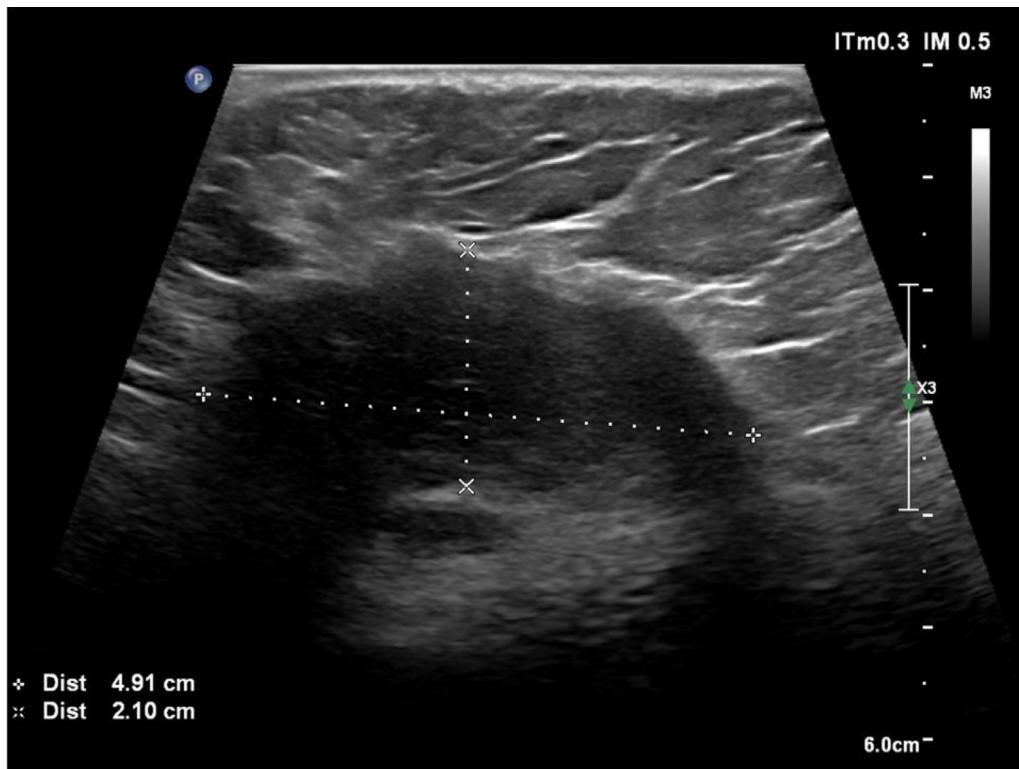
Right breast ultrasound image showing a hypoechoic, attenuating mass with spiculated margins in the junction of the inferior right quadrants.
